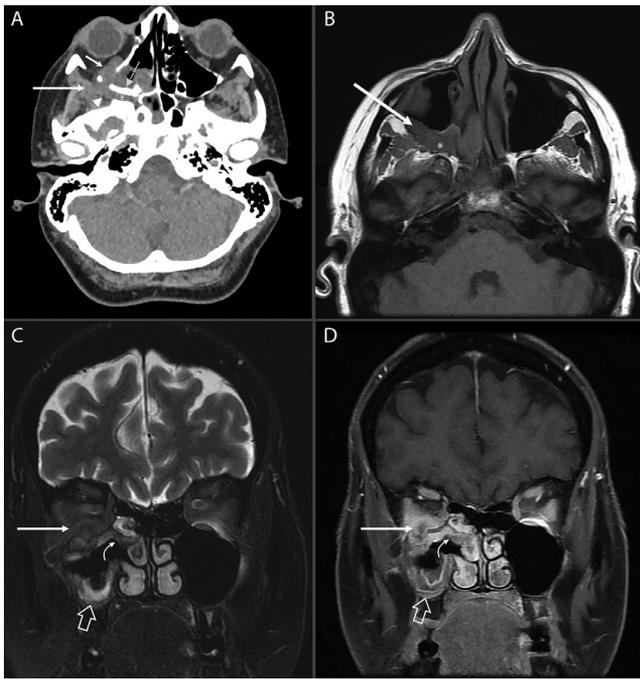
Rhino-orbital mucormycosis: 70-year-old man with history of follicular lymphoma status post chemotherapy, in remission, immunocompromised. Presents urgently with right orbital pain, proptosis and swelling, COVID positive and oxygen dependent. Failed first-line anti-fungal therapy. Subsequently underwent multiple surgeries to include: nasal endoscopy, right maxillectomy, sphenoidectomy, orbital decompression, resection of pterygopalatine fossa and pterygoid plates (postoperative images not shown). Lymphoma recurrence suspected on presentation; later pathology proven invasive fungal disease. (A) Axial, unenhanced CT of the head through the level of the orbits shows a mass centered in the right maxillary sinus invading the orbit (small white arrow), inducing mucoperiosteal thickening of the adjacent maxillary sinus bone (dashed white arrow), with extension of soft tissue into the right retroantral fat and masticator space soft tissues (long white arrow), and the pterygopalatine fossa (white asterisk). (B) T1-weighted non contrast axial image at the level of the pterygopalatine fossa shows similar soft tissue mass extending from right maxillary sinus into the retroantral fat and right masticator space (white arrow) in addition to the pterygopalatine fossa (white asterisk). (C) and (D) T2-weighted and T1-weighted post-contrast coronal images, respectively, through the orbits and middle meatus demonstrate the hypointense fungal elements invading the orbit from the maxillary sinus (white arrow). Non-enhancing mucosal soft tissue extending through the middle meatus toward the middle turbinate (curved white arrow) consistent with fungal invasion of the mucosa. Similar non-enhancing mucosal soft tissue in the inferior right maxillary sinus (white open arrow).
